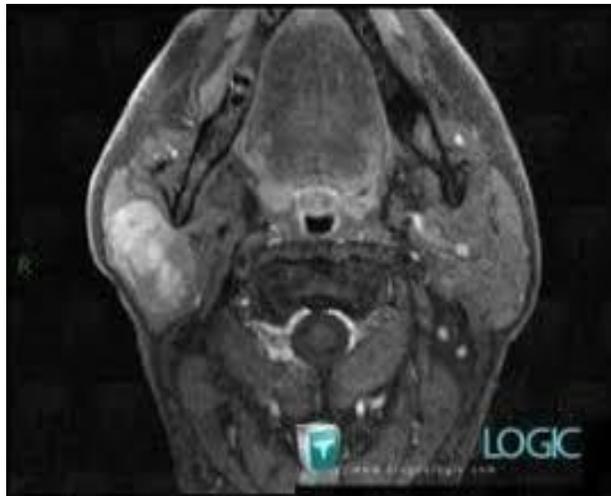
MRI showing tumor extension and right facial nerve infiltration.
